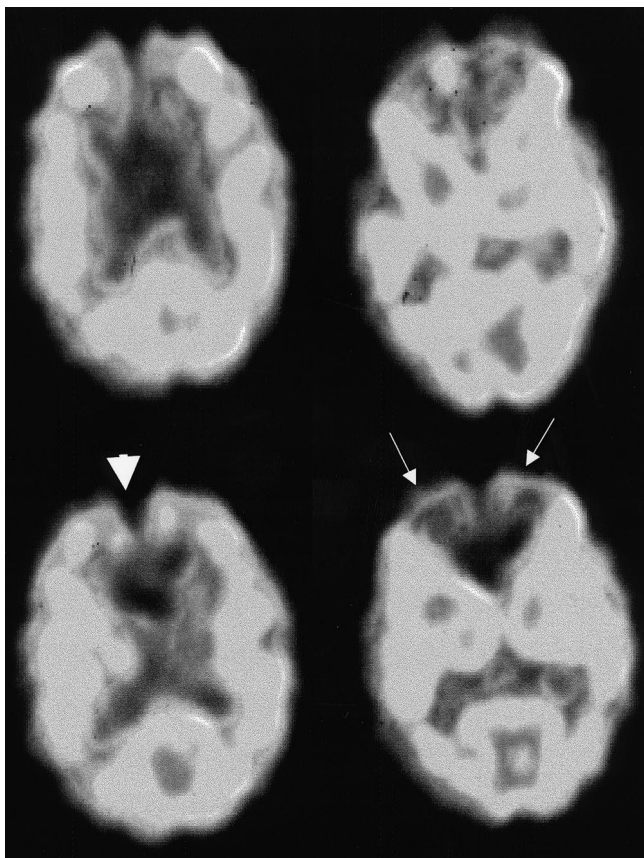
Transaxial slices of 73-y-old man with FD and 2-y history of progressive short-term memory loss show marked hypoperfusion of anterior cingulate gyrus (arrowhead) and mesial frontal lobes (arrows). MRI showed only mild frontal lobe atrophy, which could not explain brain SPECT findings.
